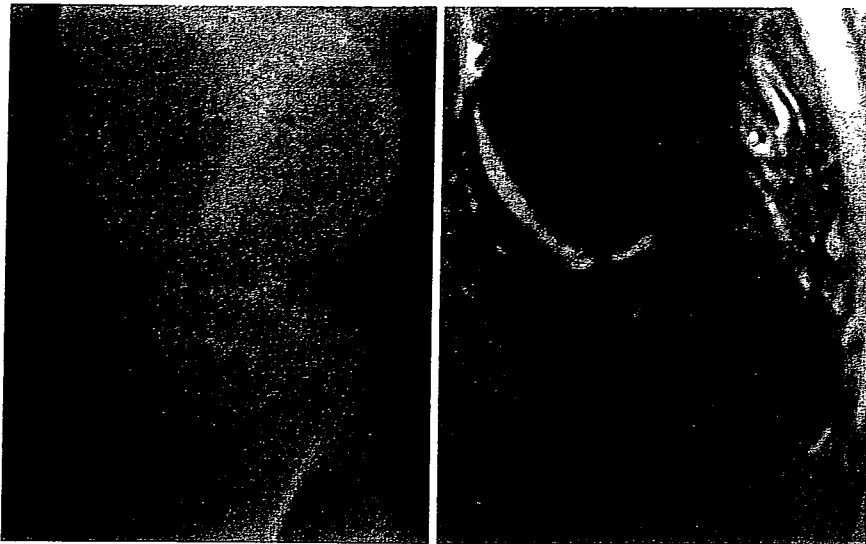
Radiographic parameters used to evaluate the positioning of the tibial tunnel in this study. The %B-A distance is the ratio of the distance between Blumensaat's line and the anterior edge of the tibial tunnel at the level of the tibial plateau (B-A) to the anteroposterior width (C). The B-T angle is the angle between Blumensaat's line and the axis of the tibial tunnel ( $\alpha$ )
